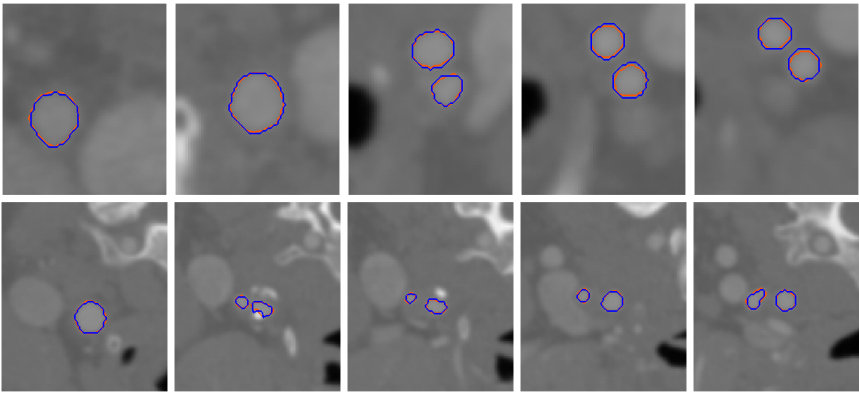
Comparison of geometry segmented from CT image dataset 1 using image slices taken along z-axis direction: blue - manual, orange - GPF deformable model.
